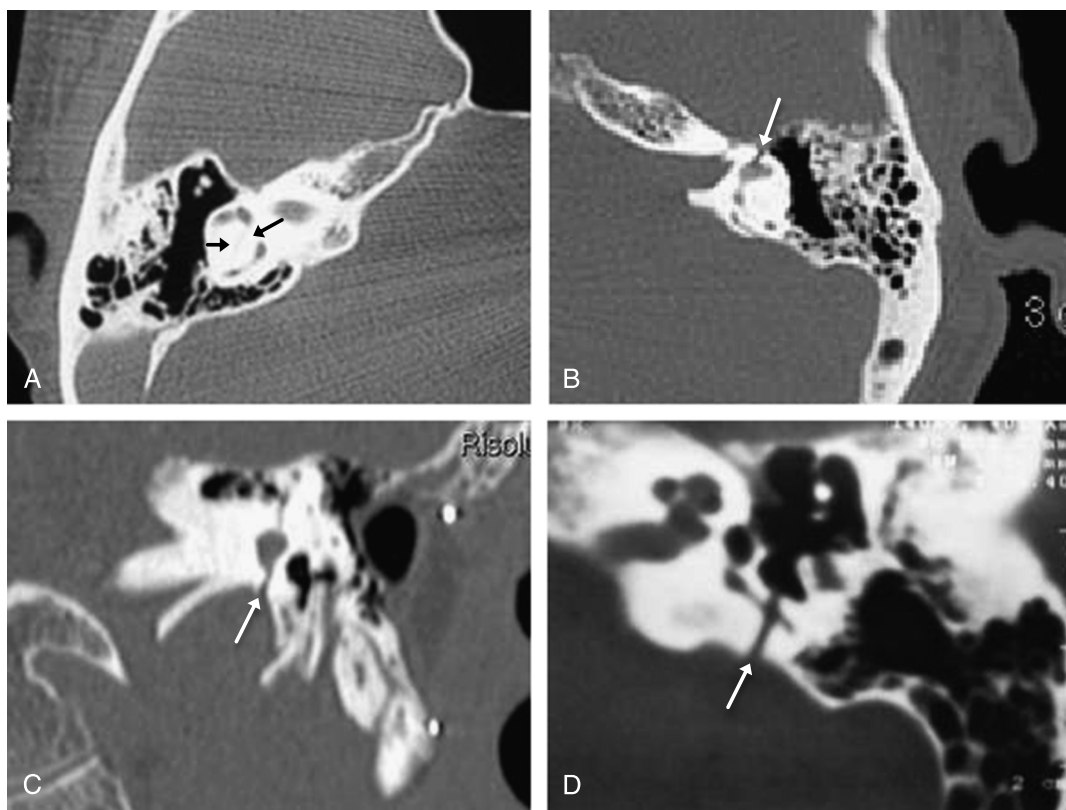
A, CT scan, axial view, right ear. Labyrinthine fracture involving the lateral semicircular canal (*black arrows*). B, CT scan, axial view, left ear. Labyrinthine fracture involving the vestibule (*white arrow*). C, CT scan, coronal view, left ear. Labyrinthine fracture involving the vestibule (*white arrow*). D, CT scan, axial view, left ear. Labyrinthine fracture involving the posterior semicircular canal (*white arrow*).
